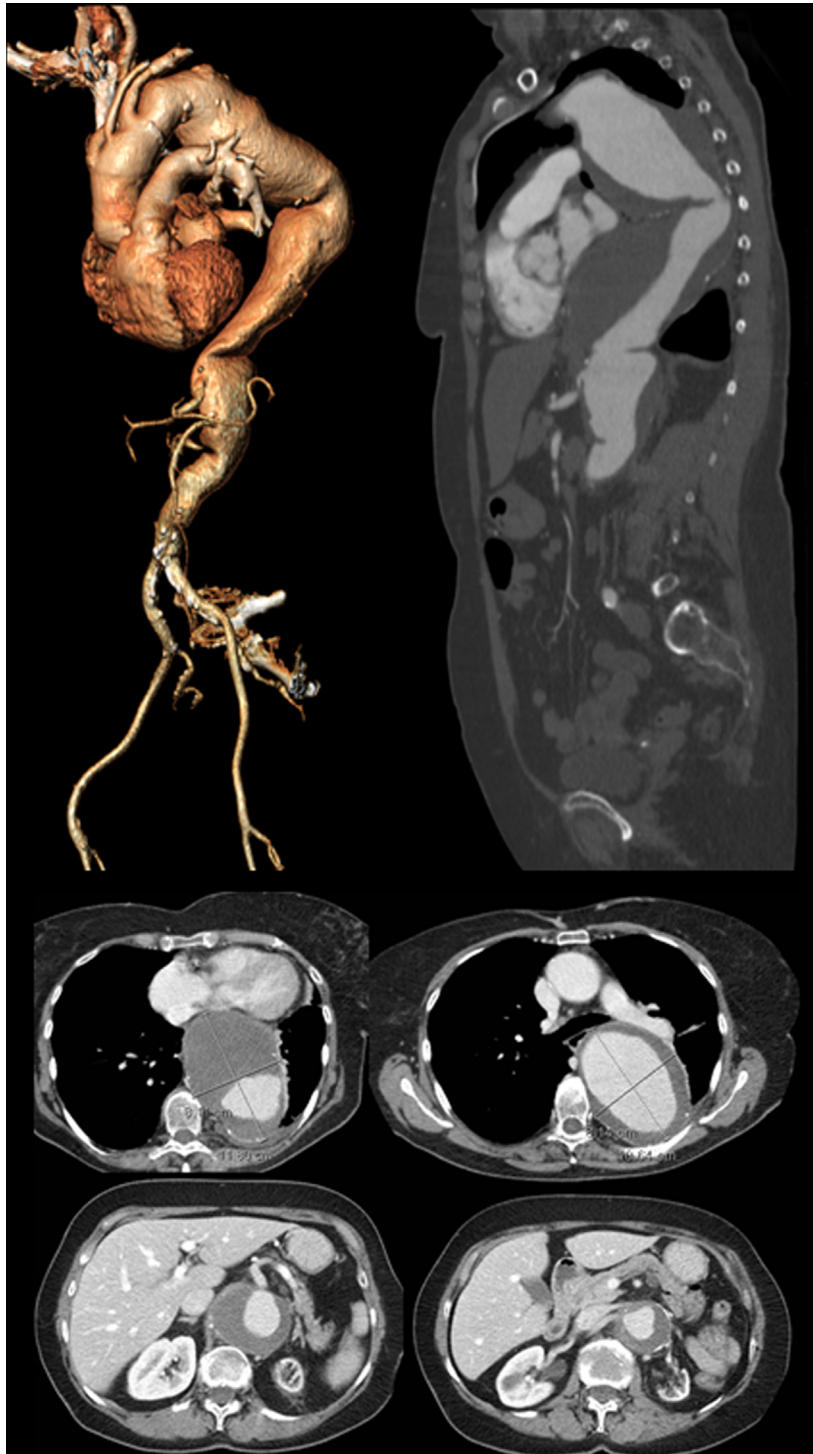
The computed tomography angiography (CTA) showed the maximum increased dilatation of 81 mm at vertebral T4-T6 and a dilatation of infrarenal abdominal aortic aneurysm of 60 mm. The size of the aortic arch at the common carotid artery was 32 mm, at the subclavian artery was 30 mm, and the length between the common carotid artery and the subclavian artery was 15 mm. The distal sealing zone, at the abdominal aortic artery, had a diameter of 26.5 mm and a length of sealing zone of 40 mm.
